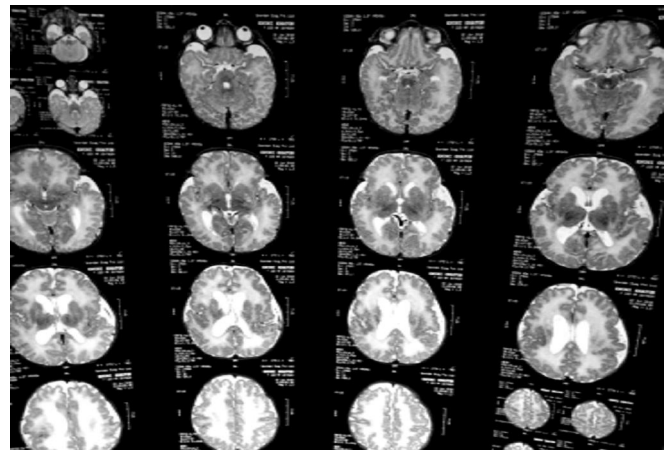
MRI images showing diffuse hyperintensity in T2WI involving both cerebral white matter with frontal predominance.
